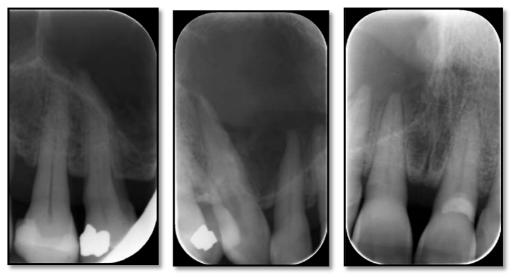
Periapical radiographs taken at the post graduate clinic 15.12.2009
